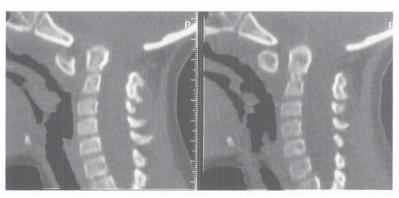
A, Occiput-C1 assimilation in a 5-year-old child with autism. There is a fixed C1–2 subluxation with an ADI of 7 mm. No neurologic deficit can be demonstrated except possible ataxia. B and C, Axial CT sections demonstrating an incomplete posterior ring of C1 and odontoid protrusion into the foramen magnum (*F*). The odontoid is seen on sections well cephalad, into the occiput. The ring of C1 (*arrows*) is invaginated up into the foramen magnum. D, Sagittal reconstruction confirming basilar impression.
